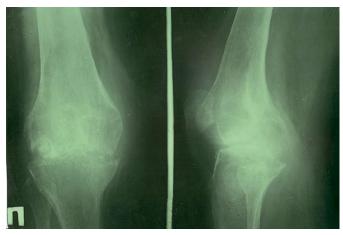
Tuberculous gonitis, bone-destructive form, peak phase. An X-ray of the knee joint shows a focus of destruction with the presence of spongy sequestration in the distal epiphysis of the femur, destruction of the articular surfaces of the femur and tibia. X-ray joint space is not visualized, periarticular soft tissues are enlarged, shading of the physiological illumination of the joint.
